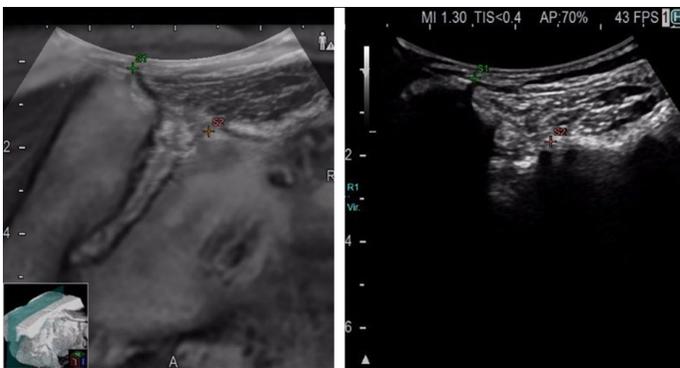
Plane and point registration at the level between S1 and S2 spinous processes for ligamentous injections. Magnetic resonance imaging on the left and real-time ultrasonography images on the right are matched by placing S1 and S2 points.
